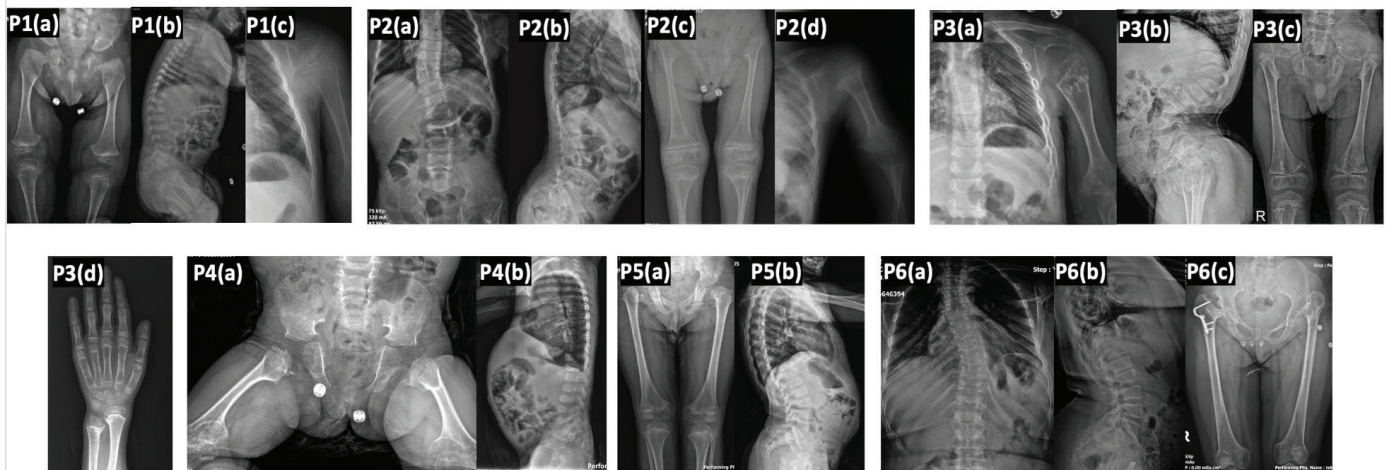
X-rays of all the patients. All tubular long bones are short. P1(a) (14 months old): Insufficient pubic ossification, absence of ossification of capital femoral epiphyses, very broad femoral necks, irregular femur distal metaphyses and epiphyses, large proximal tibiae epiphyses, short-dumbbell shaped femur, coxa valga. P1(b) (2 months): Platyspondyly with irregular vertebral endplates, mild lordosis. P1(c) (3 years old): Expanded and irregular epiphysis with mildly broad diaphysis. P2(a) (5 years old): Thoracolumbar scoliosis. P2(b): Irregular vertebral endplates, lordosis. P2(c): Small with horizontal inferior margins of the ilia, insufficient pubic ossification, absence of capital femoral epiphyses, short and broad femoral necks, coxa valga, irregular and mild flared metaphyses, irregular epiphyseal margins especially on the left side. P2(d) (2 years old): Dumbbell shaped humerus. P3(a) (10 years old): Thoracal scoliosis and enchondroma-like appearance in the proximal metaphysis of the humerus. P3(b): Platyspondyly with irregular vertebral endplates, posterior wedging of lower lumbar vertebra, kyphosis, severe lordosis. P3(c): Short ilium, horizontal acetabula, narrow and shallow sciatic notch, lack of ossification of the os pubis, absence of capital femoral epiphyses and necks, irregular metaphyses and epiphyses. P3(d): Epiphyseal and metaphyseal irregularity. Osteosclerosis and osteopenia zones at distal radius and ulna metaphyses. Carpal bone ossification is delayed. P4(a) (4 years old): Horizontal acetabula, absence of pubic ossification, absence of capital femoral epiphysis on the left side, very small capital femoral epiphysis on the right side, short-dumbbell shaped femur, irregular and enlarged metaphyses. P4(b) (1 year old): Platyspondyly with irregular vertebral endplates (pear-shaped appearance). P5(a) (5 years 10 months old): Absence of capital femoral epiphyses, multicentric ossification of right femoral neck, small and irregular femoral necks, coxa valga, small proximal tibia epiphyses. P5(b): Flattened with pear-shaped vertebrae and lordosis. P6(a) (mother of Patient 5): Thoracal scoliosis. P6(b): Platyspondyly with irregular vertebral endplates, posterior wedging of lower lumbar vertebra, lordosis. P6(c): Irregular margins of ilia, shallow acetabular fossa, irregular ossified (deformed) femoral necks, absence of femoral heads
